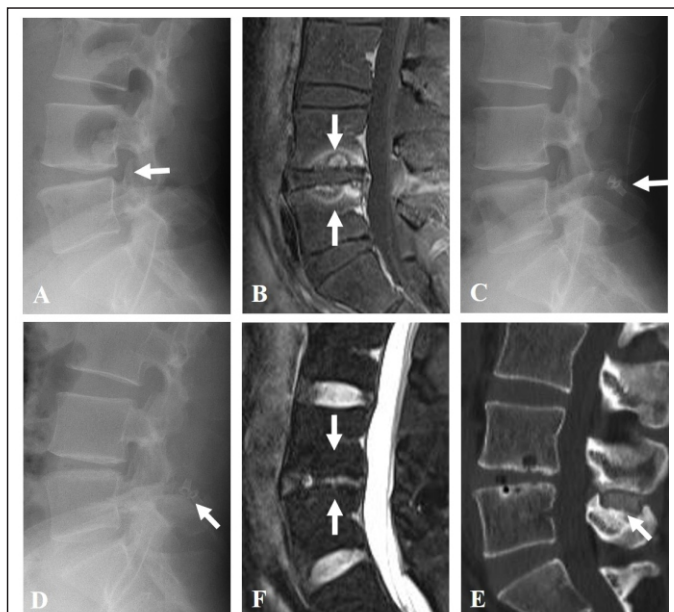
Neutral (a) lateral radiograph shows that segmental imbalance, such as hyperlordosis and retrolisthesis, at L4-5. Magnetic resonance image (b) shows internal disc derangement with severe modic change at L4-5 segment. Post-operative lateral radiograph (c) shows DIAM implantation with restoration of segmental lordosis at L4-5 segments. At 13 years after surgery, follow-up lateral radiograph (d), magnetic resonance image (e), and computed tomogram image (f) show well maintenance of segmental lordosis and DIAM implant at L4-5 with resolution of internal disc derangement with severe modic change.
